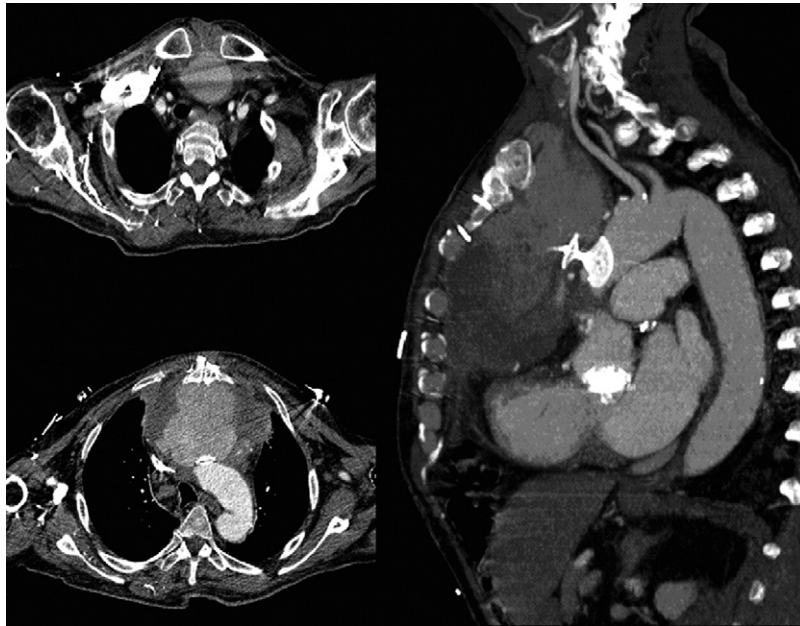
Preoperative computed tomography scan showing the voluminous pseudoaneurysm after failed tentative exclusion with Amplatzer devices.
